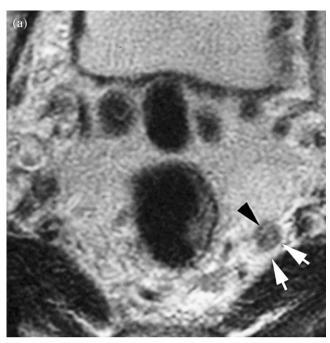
Nodal downstaging after chemoradiation. (a) Pretreatment T2-weighted magnetic resonance image showing several malignant nodes in the right mesorectum (arrows) and a polypoidal mass in the mid-rectum. (b) After chemoradiation treatment, there was downsizing of the primary tumor. In addition, the malignant nodes demonstrated on the pretreatment imaging showed complete regression. The nodal status was found to be N0 after surgery.
